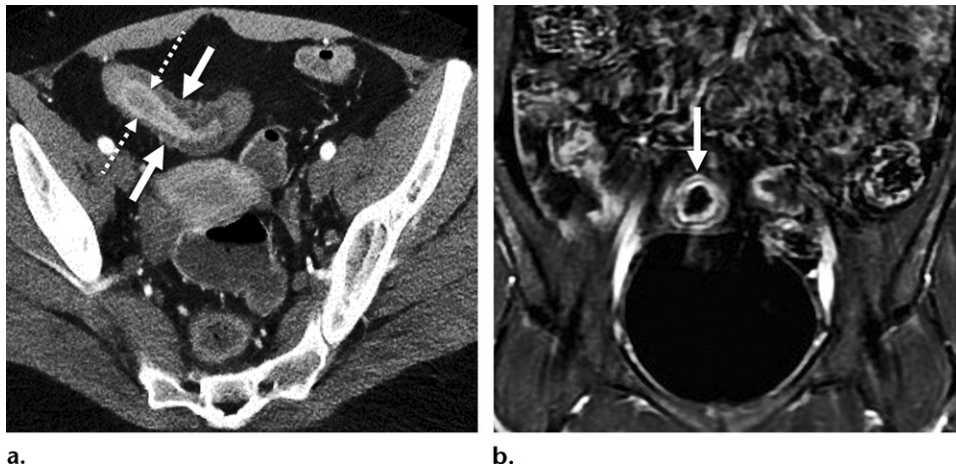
Stratified (bilaminar or trilaminar) mural hyperenhancement. (a) Axial contrast-enhanced CT enterographic image with neutral oral contrast material shows stratified (bilaminar) mural hyperenhancement with small bowel wall thickening (solid arrows), hyperenhancement of the inner aspect of the bowel wall (dashed arrows), and luminal narrowing, findings consistent with active inflammatory Crohn disease with luminal narrowing. (b) Coronal contrast-enhanced fat-suppressed T1-weighted MR enterographic image with biphasic oral contrast material in a different patient shows small bowel wall thickening with stratified (trilaminar) mural hyperenhancement (arrow), findings consistent with active inflammatory Crohn disease.
